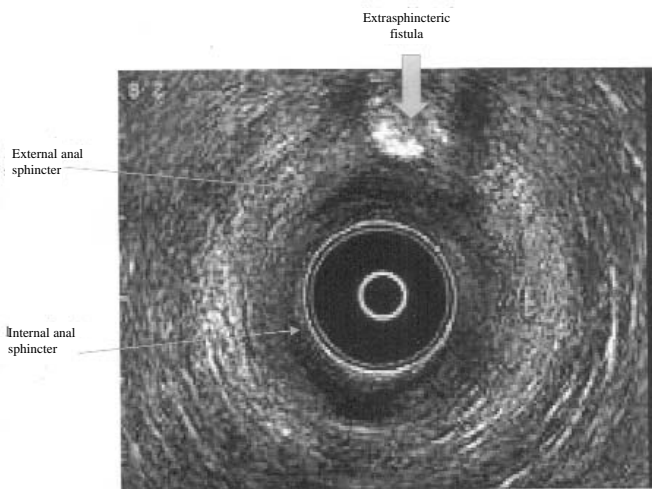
Hydrogen peroxide-enhanced axial endoanal ultrasound showing an extrasphincteric anal fistula (arrowhead).
